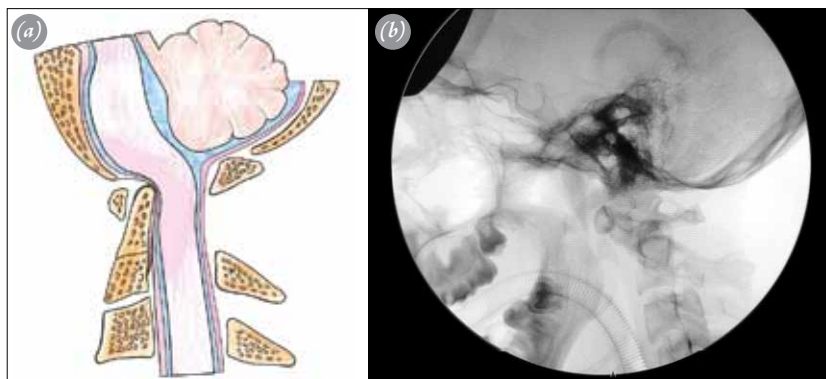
(a) Compression of the spinal cord with scissoring effect at the dislocation site. (b) Radiography of AAD showing widened interspinous interval of C1-C2. [Color figure can be viewed in the online issue, which is available at www.aott.org.tr]
